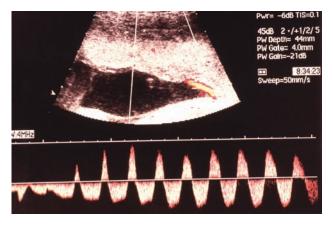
Arterioarterial anastomoses can be diagnosed *in utero* by the typical bidirectional pulsatile flow seen by Doppler study
